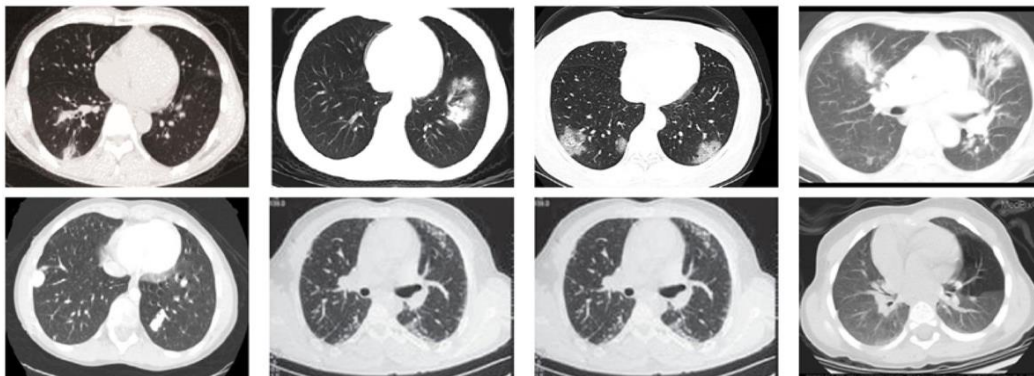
Relevant examples of CT images in COVIDx CT-2
